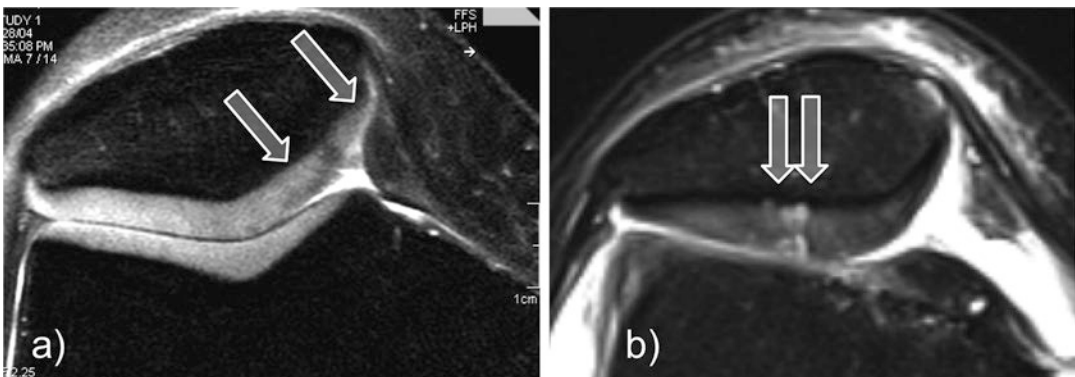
High-resolution morphological fsPD-TSE axial MR images of the patellofemoral joint as performed on a 3.0 Tesla MRI with an in-plane resolution of 0.4×0.4 mm. The left image (a) shows abnormal cartilage with lesions
